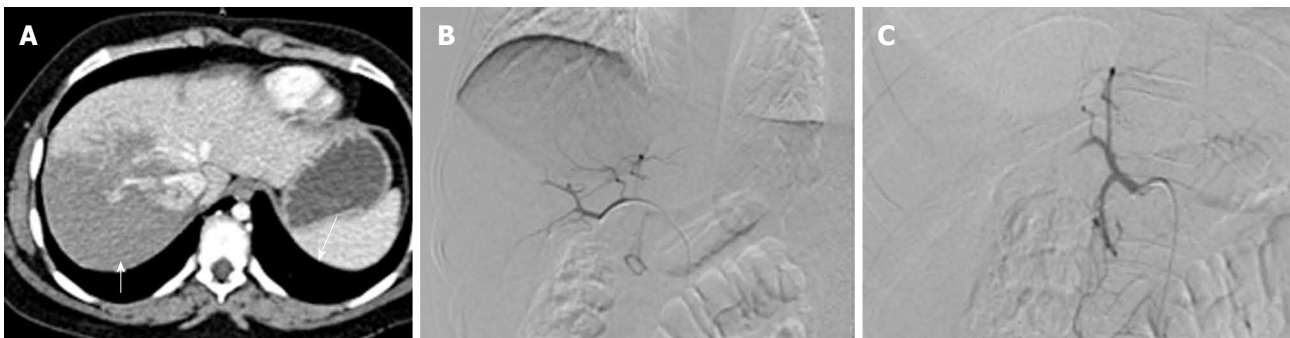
Prophylactic embolization of right hepatic artery in high grade liver injury. A: CECT abdomen of a 35 years old male, c/o BTA showed extensive deep lacerations and intraparenchymal contusions in the right lobe of liver s/o Grade IV injury. Majority of these lacerations were reaching upto the hepatic surface (arrow) with possible capsular breach. Mild hemoperitoneum was present in pelvis; no active contrast extravasation or pseudoaneurysm; B: In view of high grade injury involving right lobe, prophylactic gelfoam embolization of right hepatic artery was done; C: Post embolization, there was non-opacification of RHA. CECT: Contrast enhanced computed tomography; BTA: Blunt trauma abdomen; RHA: Right hepatic artery.
